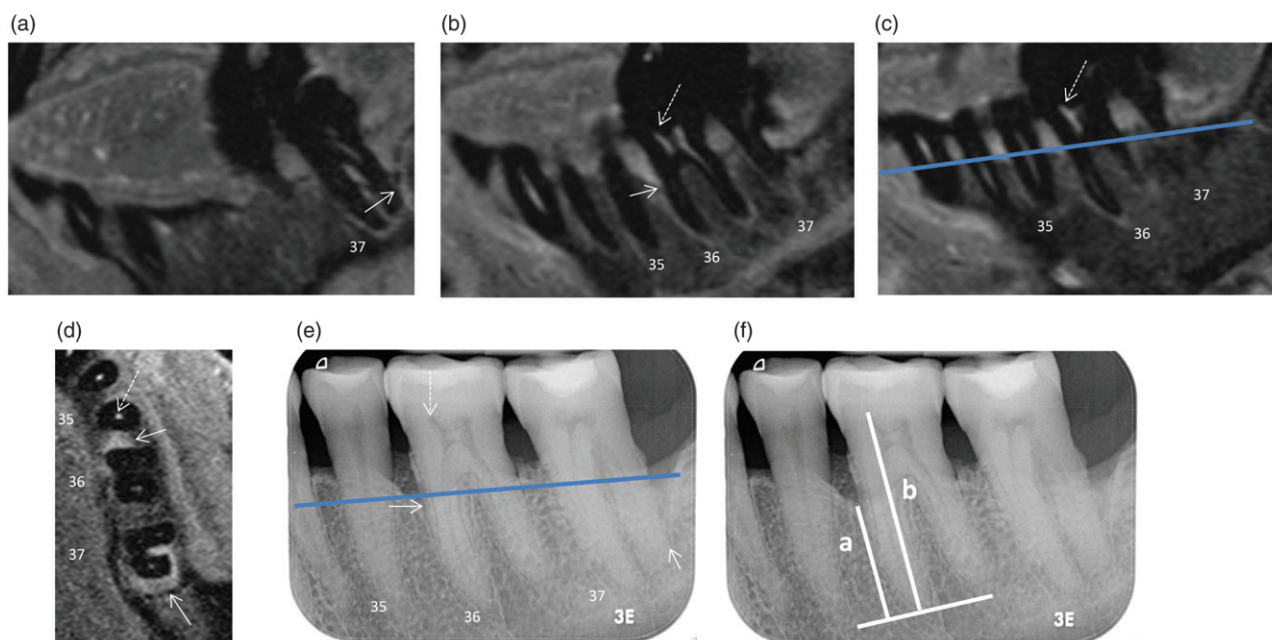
T1-DMR images of the left jaw parasagittal with contrast agent (Dotarem). (a–c) Parasagittal images scrolled from oral to buccal. White arrows: bottom of the distal bony defect (least residual periodontal bone support) of teeth 36 and 37, white interrupted arrows: pulp of teeth 36 and 37. The deepest point of the least mesial residual periodontal bone support of tooth 36 can be seen in (b) and the least distal residual periodontal bone support of tooth 37 can be seen in (a). (d) According axial images at the level of the blue line. Interestingly, one can see that the mesial defect of at tooth 36 is located more to the lingual aspect of root, whereas the distal defect of tooth 37 involves even the furcation area. (e) According periapical radiograph (f) Measurement in PA-radiographs: a : distance from the apex to the bottom of the bony defect, b : distance from the apex to the top of the pulp horn, $q = a/b$. The same measurements were performed in the MR images (Figure 2).
